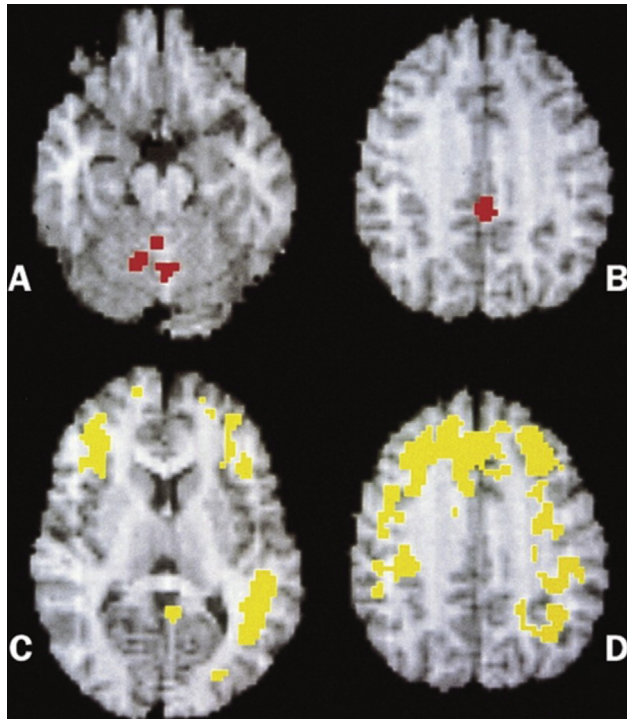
SPECT findings during a sleepwalking episode. In relation to data from normal volunteers during wakefulness ($n = 24$), large areas of frontal and parietal association cortices remain deactivated during sleepwalking. SPECT findings during sleepwalking after integration into the appropriate anatomical magnetic resonance image. The highest increases of regional cerebral blood flow ($> 25\%$) during sleepwalking compared with quiet stage 3 to 4 NREM sleep are found in the anterior cerebellum – that is, in the vermis (A), and in the posterior cingulate cortex (Brodmann area 23 [Tailarach coordinate $x = 4, y = 40, z = 31$], B). Note the inclusion of the dorsolateral prefrontal cortex (C), the mesial frontal cortex (D), and the left angular gyrus (C) within these areas.
